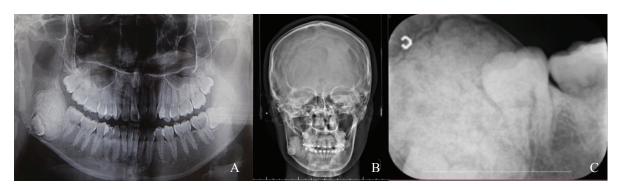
shows (A) panoramic, (B) PA skull, (C) periapical radiograph with a well-defined amorphous radiopaque mass at the right mandible. The mandibular right third molar and inferior alveolar canal are displaced. The mandibular right second molar has intact lamina dura and no root resorption.
